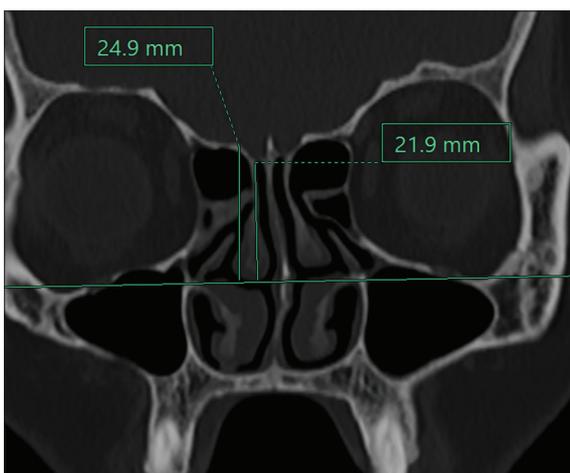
Reformatted coronal computed tomography scan showing measurement of olfactory fossa depth. A line was drawn parallel to the highest point of the maxillary sinus at the bony boundaries of the infraorbital foramina. Perpendicular lines were drawn to the inferior (arrow) and superior borders (arrowhead) of the lateral lamella. The distance between these lines is 3.0 mm (type I keros)
